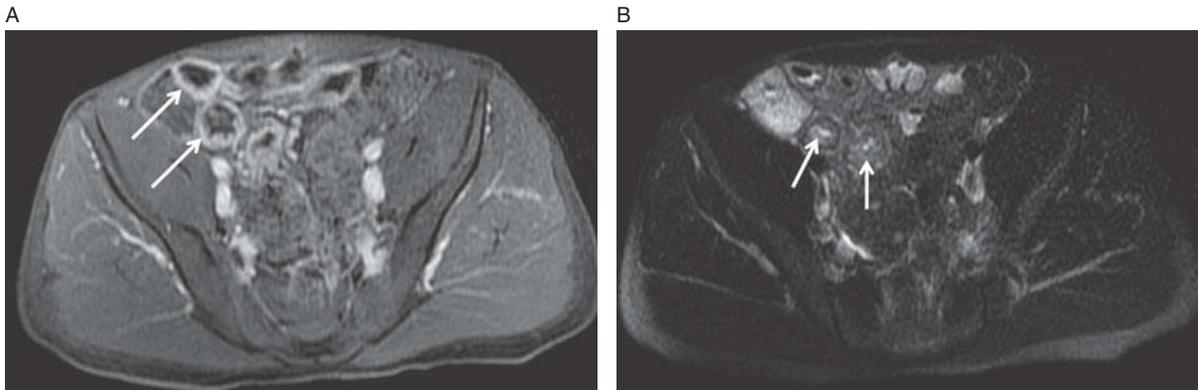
Axial T1-weighted, fat-saturated post-contrast image (A) shows multiple loops of abnormally enhancing distal ileum (arrows). The abnormalities are easiest to see on post-contrast images. Then, go back to the T2-weighted images to assess activity. In this patient, the T2-weighted image (B) demonstrates elevated T2-signal within the bowel wall indicating active inflammation.
